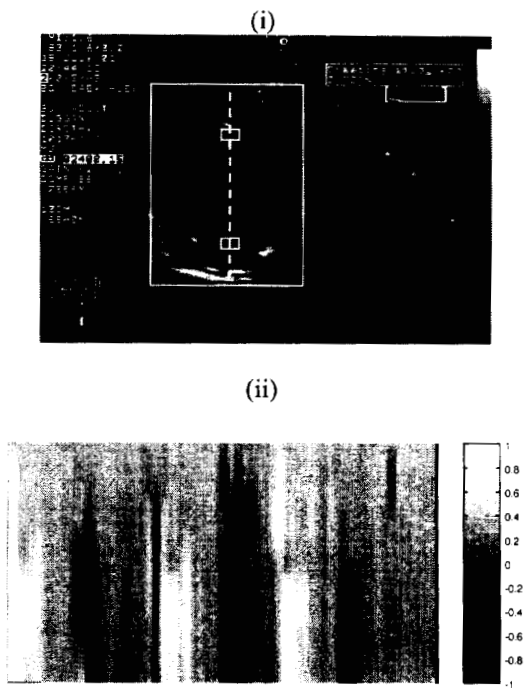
i) Sonogram and ROI of infarcted case I (long-axis view), ii) M-mode displacement image along the dotted line on the sonogram of (i); iii) Displacement profiles at the infarcted (dotted; top small square on (i)) and non-infarcted (solid; bottom small square on (i)) regions, as noted on (i); iv) M-mode elastogram at the same region as (ii) v) Strain profile at the same regions as (iii). Note that the top of (ii) and (iv) show low motion and deformation, respectively since they correspond to the infarcted region.
